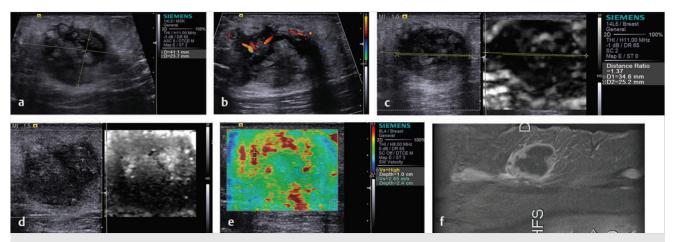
A 38-year-old female presents with a palpable mass in her upper arm. (a) On B-mode ultrasound the mass is heterogeneous with a central area that is more hypoechoic and a rim of increased hyperechogenicity. The mass measures 4.1 cm. (b) On color Doppler it demonstrates the presence of moderate blood flow in the mass. (c) On SE the mass including the peripheral area of hyperechogenicity is very stiff. The lesion has a heterogeneous pattern of stiffness. (d) A strain image obtained using ARFI technology (VTI, Siemens Ultrasound, Mountain View, CA) is similar to the SE image. (e) The mass on 2D-SWE is heterogeneous in stiffness with a maximum stiffness value of >6.5 m/s. (f)The same mass on T1-weighted gadolinium-enhanced MRI demonstrates enhancement in the periphery of the mass. On surgical pathology, the mass was found to be a squamous cell carcinoma.
